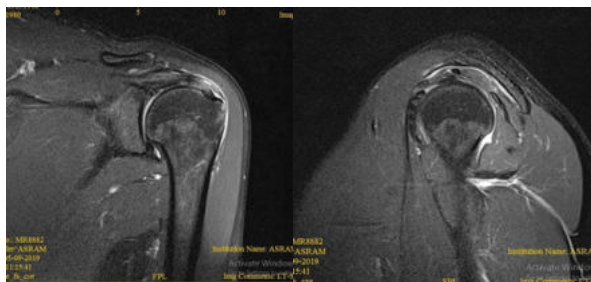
MRI Coronal and Saggital proton density fat saturated images of shoulder joint showing partial supraspinatus tear associated with type III acromion process.
